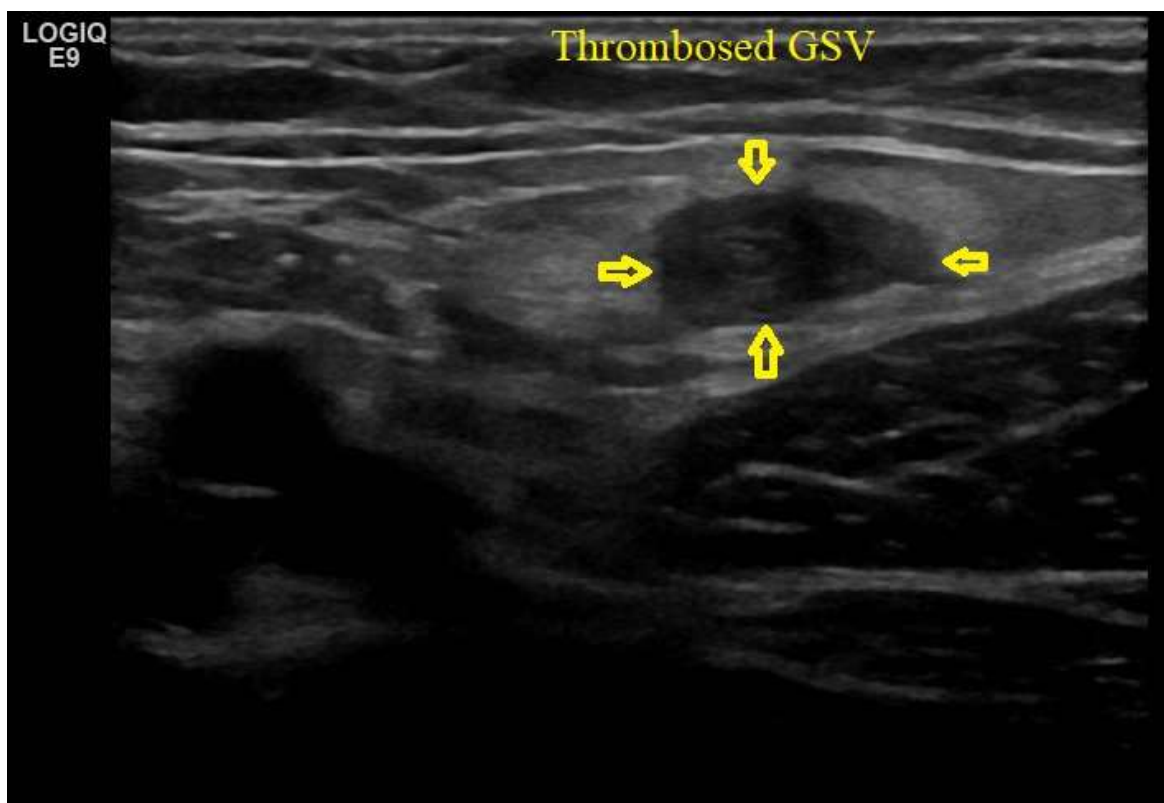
Ultrasound done after one month follow up revealed thrombosis of the GSV.
